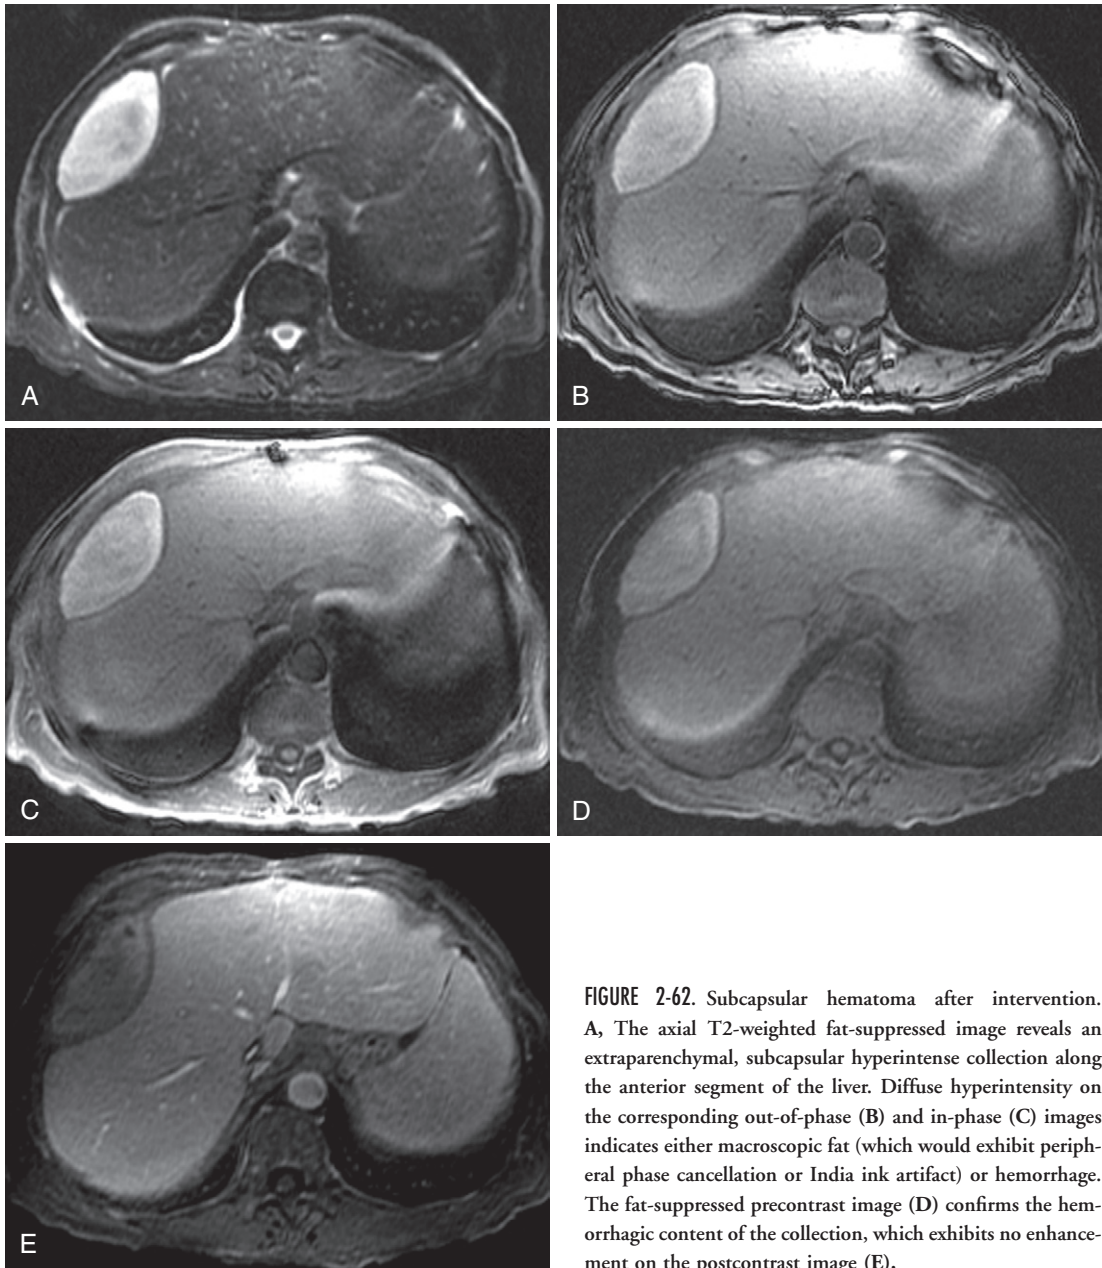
Subcapsular hematoma after intervention. A, The axial T2-weighted fat-suppressed image reveals an extraparenchymal, subcapsular hyperintense collection along the anterior segment of the liver. Diffuse hyperintensity on the corresponding out-of-phase (B) and in-phase (C) images indicates either macroscopic fat (which would exhibit peripheral phase cancellation or India ink artifact) or hemorrhage. The fat-suppressed precontrast image (D) confirms the hemorrhagic content of the collection, which exhibits no enhancement on the postcontrast image (E).
